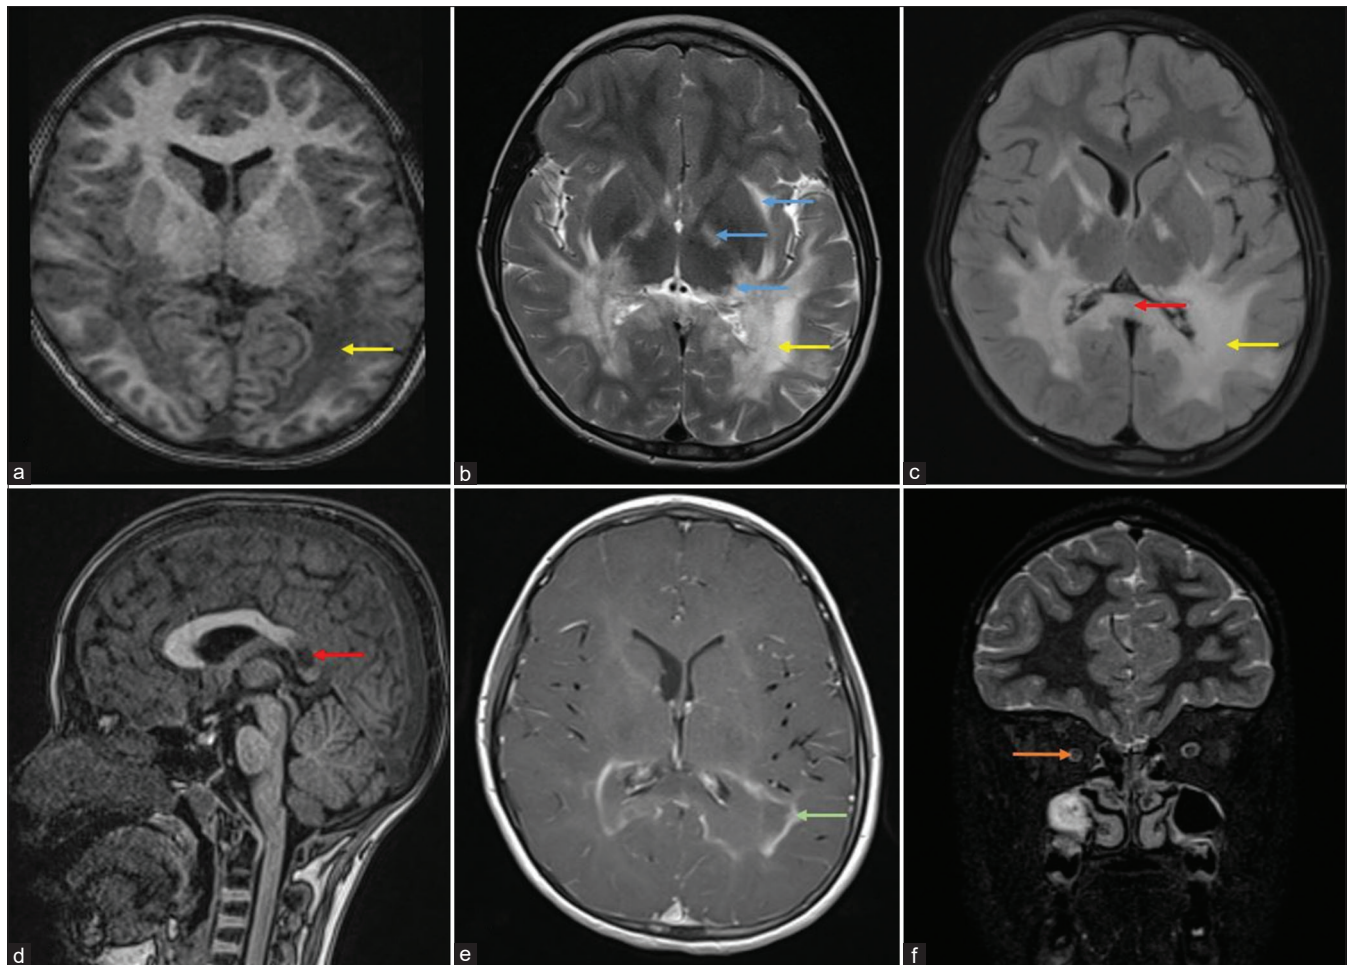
Magnetic resonance imaging of brain shows bilateral symmetric confluent areas of hypointensities on T1 (a) and hyperintensities on T2 (b) and FLAIR sections (c) involving parieto-occipital white matter (yellow arrows), splenium of corpus callosum (c, d-red arrow), external capsule, internal capsule, pyramidal tracts, and lateral geniculate area of the thalamus (B-blue arrows). Post-contrast study (e) shows typical peripheral enhancement (green arrow) at the mid-zone of the parieto-occipital white matter suggesting active inflammation. STIR coronal image (f) showing subtle hyperintensity involving bilateral optic nerves (orange arrow)
